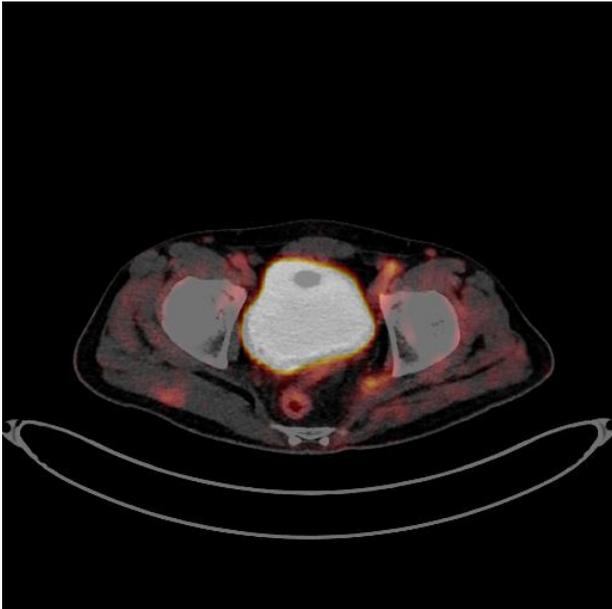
PET-CT. Focal mild hypermetabolism in the left femoral nerve.
